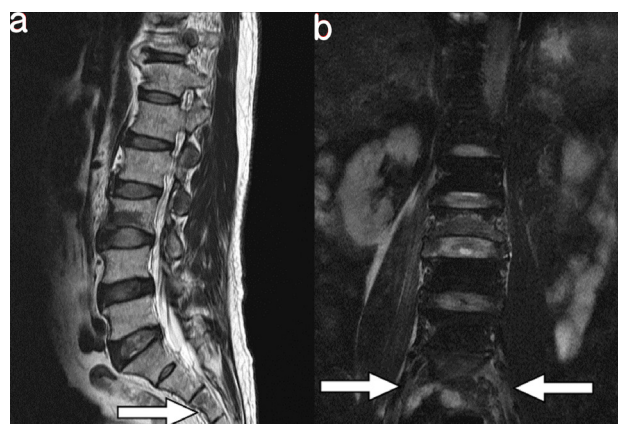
MRI (a, T2-weighted sagittal view; b, T2-weighted coronal view) of a 67-year-old male with sacral insufficiency fracture. SIF involve S3 body level (white arrow) and transverse alar area (white arrowheads)
